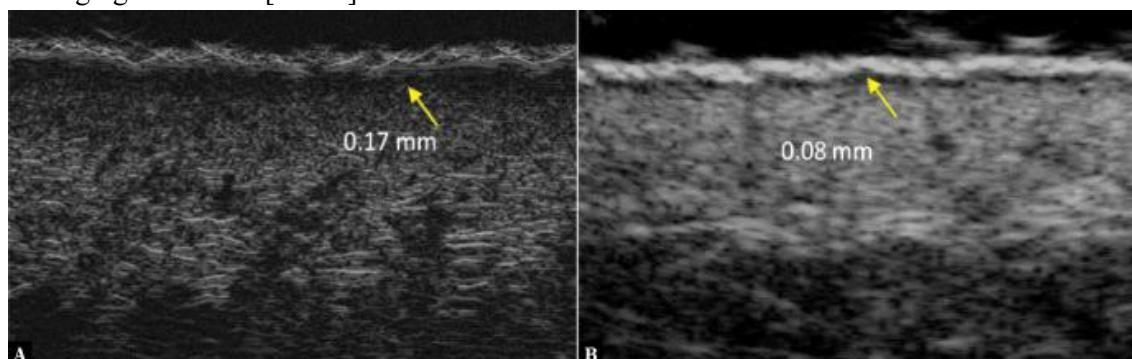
The arrows in the figure indicate the SLEB in the ultrasound image of healthy skin. A. Forehead skin, 50 MHz probe. B. Hand skin, 48 MHz probe [11].
